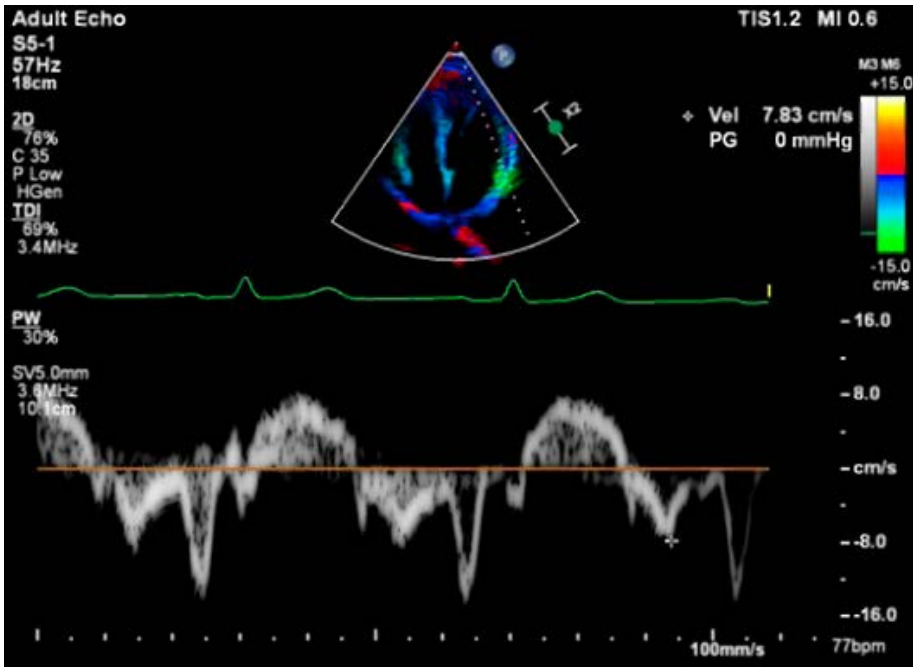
Tricuspid lateral annular systolic velocity wave (S') evaluation from the apical four-chamber view using tissue doppler.*
